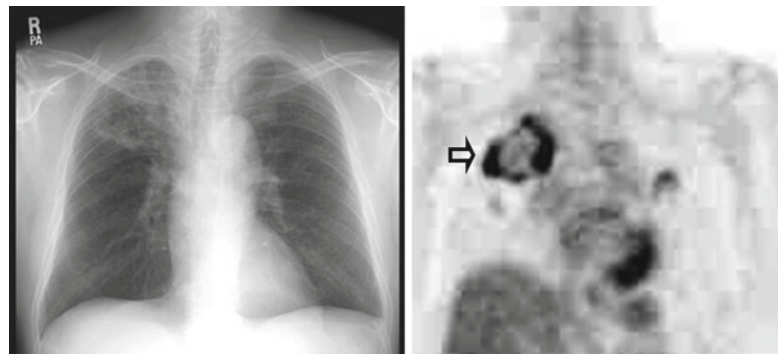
(a) Chest radiograph of a patient undergoing evaluation of esophageal cancer showed active pulmonary tuberculosis in the right upper lung. (b) FDG PET scan demonstrates intense uneven FDG uptake in the lung lesion (*arrow*)
